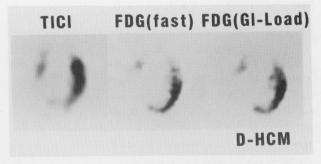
Both fasting and glucose-loading F-18-FDG images in a 60-year-old woman with dilated phase HCM demonstrate antero-septal and apical uptake defect.
